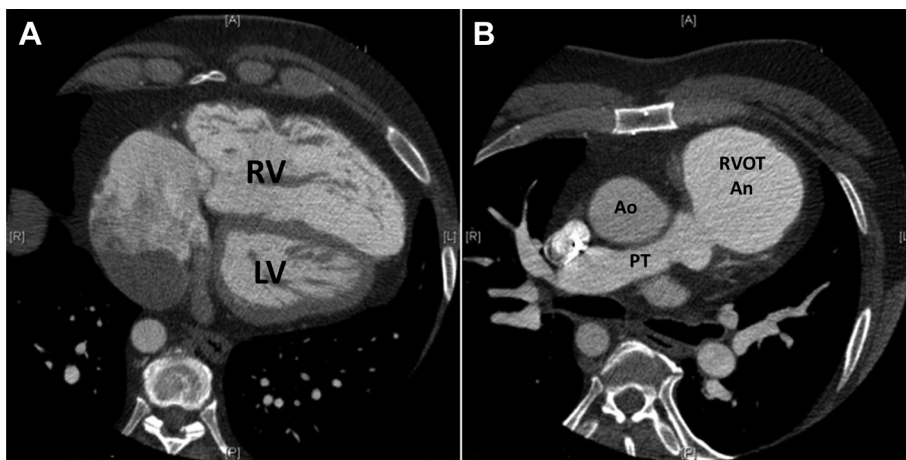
Computed tomographic imaging of the heart in the patient described before cardiac transplantation. (A) View showing the right ventricular cavity (inflow portion) and the much smaller left ventricular cavity (LV). The dilated right atrium is also seen as well as the right-sided aortic arch (Ao). (B) A view showing the marked dilatation of the outflow portion of the right ventricle (RV) just beneath the pulmonic valve (PV). PT = pulmonic trunk; RVOT An = right ventricular outflow tract aneurysm.
